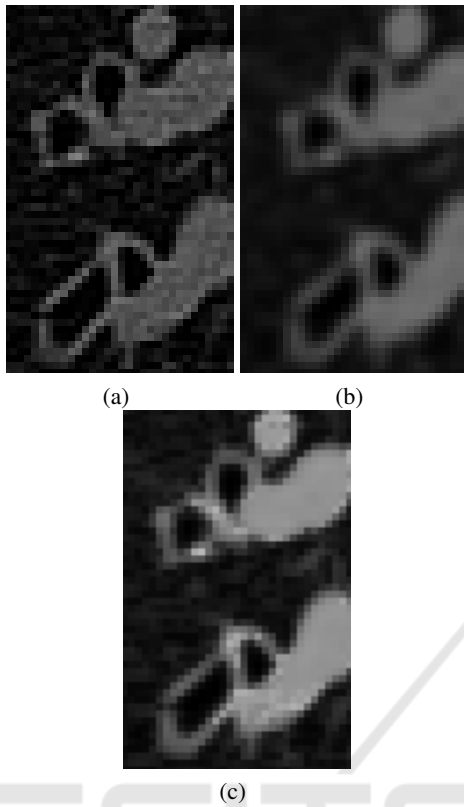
Three CT images reconstructed using (a) hard filter and (b) soft filter (c) the fusion of the data using soft and hard kernel. Airways appear in CT image as a dark structure surrounded by a bright and thin contour. Airways shown here belong to the 6th generation.
